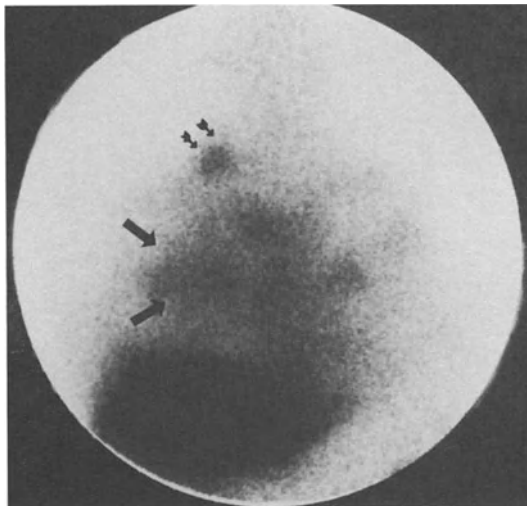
Complete conventional investigation of another patient with rising serum CEA level failed to uncover a metastatic lesion recurrence. However, immunoscintigraphy using In-111 ZCE-025 detected abnormal uptake in the lower abdomen anteriorly near the midline (arrows) in this planar anterior pelvis view. Note the testicular uptake (double arrow), a normal finding in some patients.
